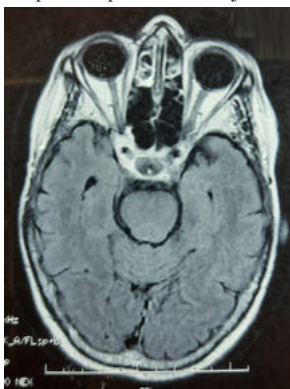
Axial slice of T1 Fat Saturation weight brain magnetic resonance imaging, showing complete disappearance of the sphenoid process
